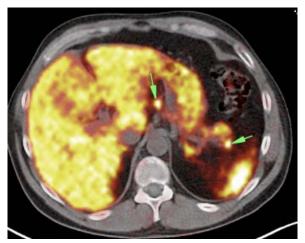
PET-CT with 68Ga shows that the tumour from Figure 1 exhibit overexpression of somatostatin receptors.
